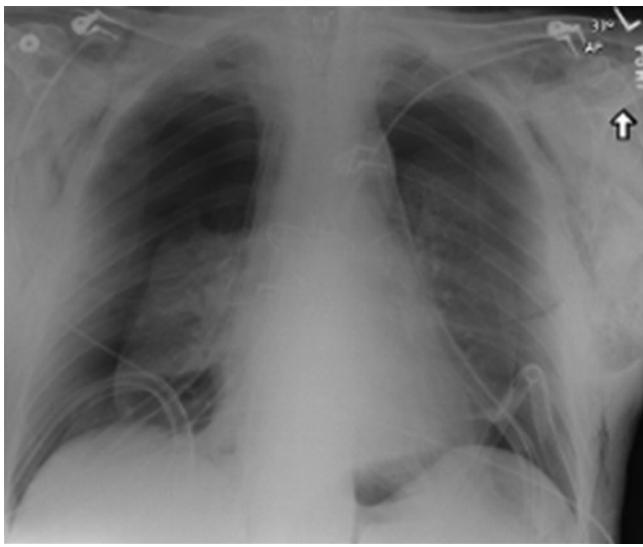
The chest radiograph of a patient with right-sided pneumothorax and bilateral chest tubes.
